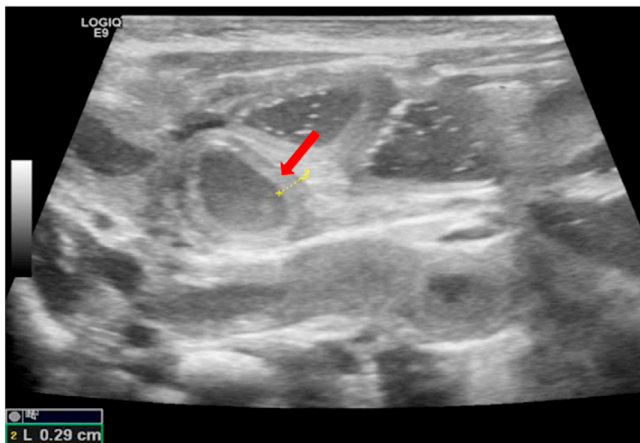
Ultrasound images showing a small bowel distension and bowel wall thickening (red arrow) upstream the intussusception.
